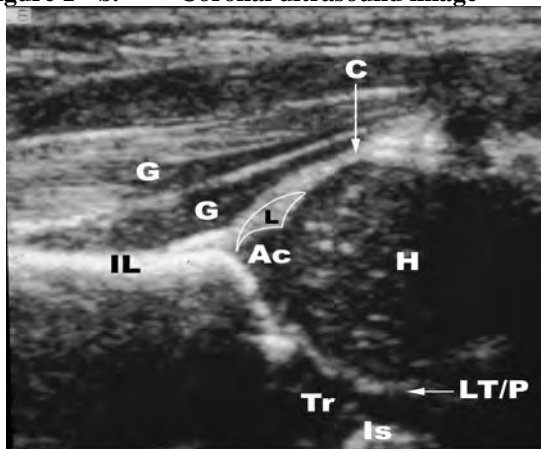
b. Coronal ultrasound image
